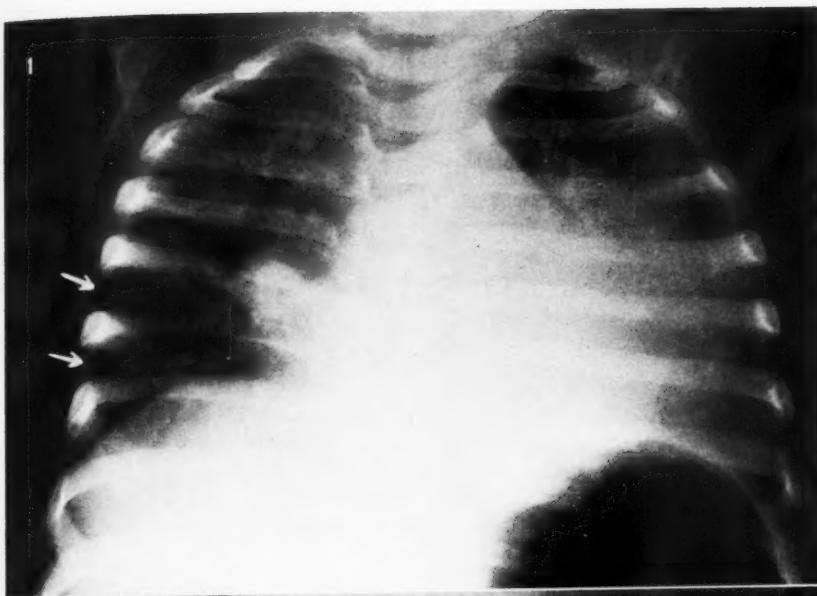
S. S., age 12 months. Dyspnea, cough, and fever one week before admission. Chest roentgenogram (anteroposterior erect) showing inflammatory changes in the left and right lung parenchyma. Note marked intercostal bulging, especially in the 5th and 6th right intercostal spaces, with marked radiolucency (arrows).
